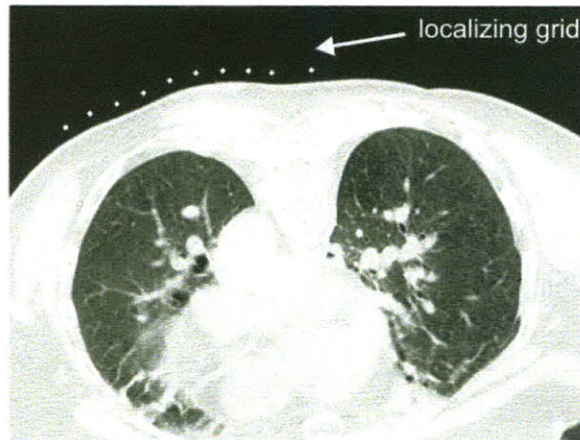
A representative CT scan showing both lungs and the localizing grid placed over the right lung.
